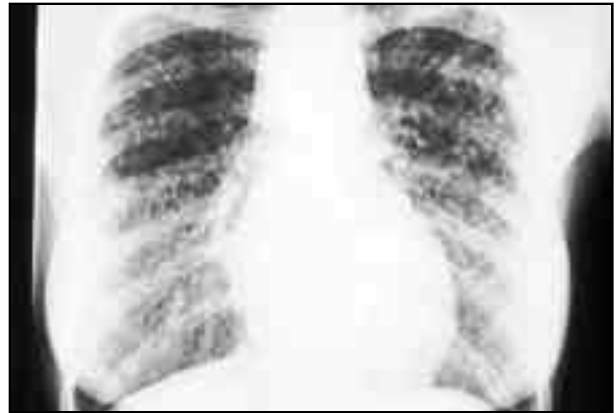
X-ray Chest showing small nodular opacities all over the chest, suggesting disseminated pulmonary tuberculosis
